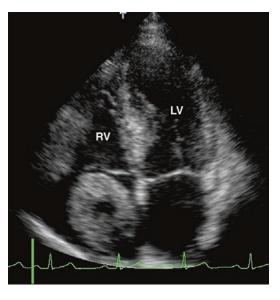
Apical four-chamber projection showing a large thrombus in the right atrium. *LV* Left ventricle, *RV* right ventricle
